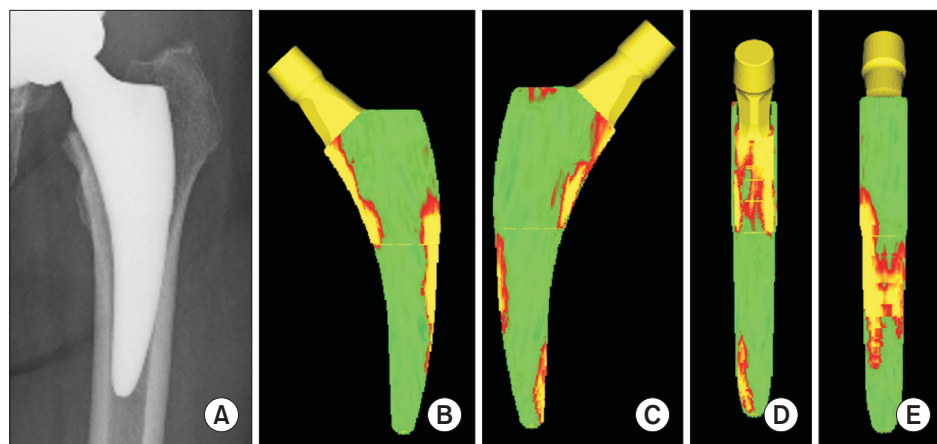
Visual assessment for Fitmore by density mapping. (A) Postoperative radiograph. (B) Anterior-posterior view. (C) Posterior-anterior view. (D) Medial view. (E) Lateral view.
